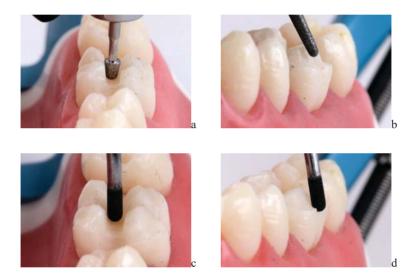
(a–b) Refining the pulpal floor and the cusp reduction with fine granulation diamond burs. (c–d) Refining the walls with an ultrasound tip.
